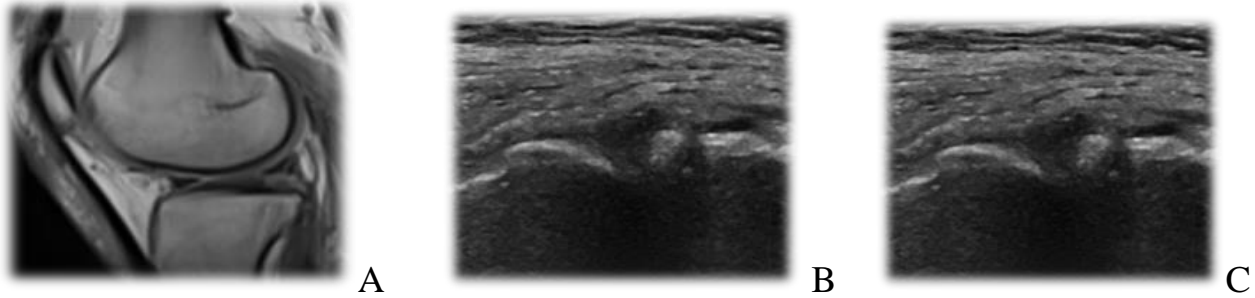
A. US image of PHLM tear, B, C, MRI images PD and PD fat suppression of PHLM tear
